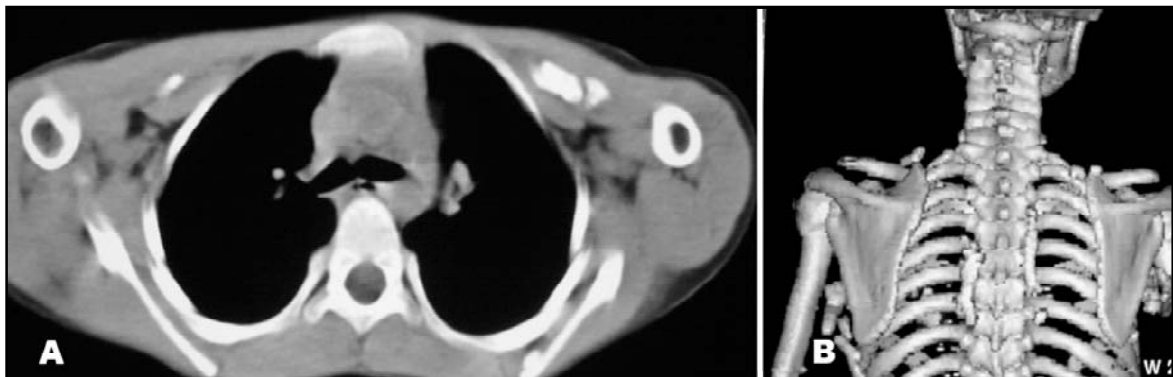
(A) Axial CT scan of the thoracic region and (B) a three dimensional reconstruction of the trunk showed heterotopic ossifications.
